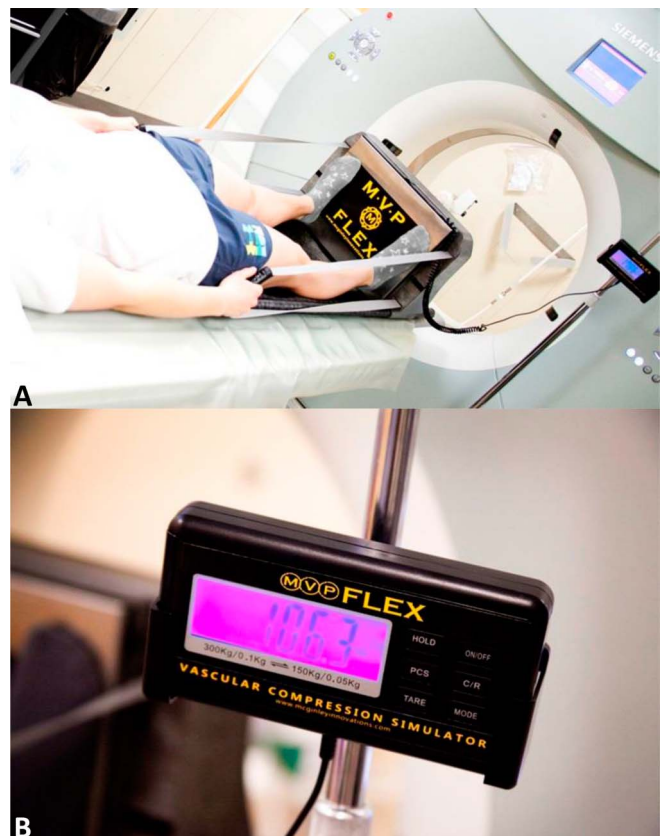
Patient positioning for CTA stress imaging. (A) The patient is positioned supine on the MVP Flex with the hand straps taut and feet plantar flexed against the pressure plate. B, Plantar flexion force generation was maintained between 100 and 140 pounds CTA, CT angiography.
